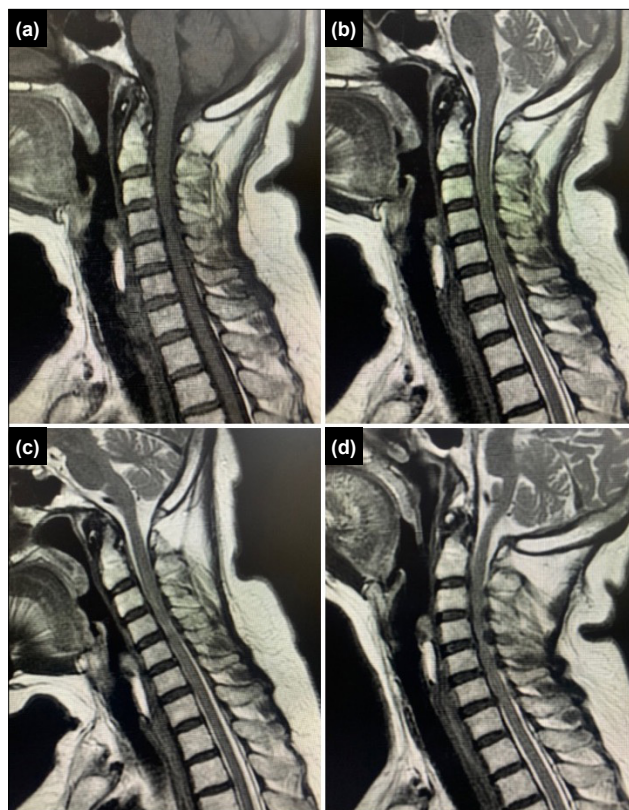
(a) Preoperative T1-weighted magnetic resonance imaging (MRI) in the neutral position. (b) Preoperative T2-weighted MRI in the neutral position. (c) Preoperative T2-weighted MRI in flexion. (d) Preoperative T2-weighted MRI in extension.
